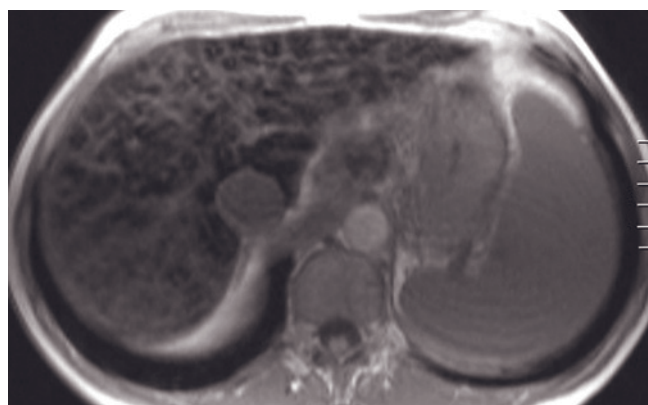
Idiopathic hemochromatosis, advanced disease. Transverse (a) and coronal (b) SGE and coronal 45-s postgadolinium SGE (c) images. The precontrast T1-weighted image (a) demonstrates signal-void liver and pancreas (arrows, a). The coronal SGE image (b) also demonstrates low-signal-intensity left ventricular myocardium (arrow, b). On the 45-s postgadolinium image (c), multiple enhanced varices are shown (arrows, c), which reflects portal hypertension secondary to cirrhosis.
